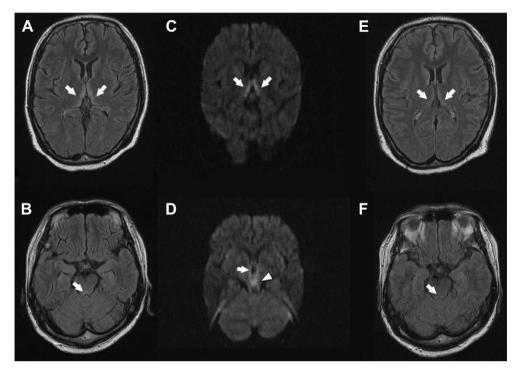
(A, B) Axial fluid-attenuated inversion recovery (FLAIR) images show abnormal hyperintensity within the medial thalami area surrounding the third ventricle (arrows in A) and pontine tegmentum (arrow in B). (C, D) Diffusion-weighted images (DWIs) show highly hyperintense areas within the bilateral thalami (arrows in C), periaqueductal area (arrow in D) and mammillary bodies (arrowhead in D) but no abnormal signal intensity in the other brain regions. These lesions on DWIs are more clearly visible than on the conventional T2-weighted image. (E, F) Post-treatment axial FLAIR images show that the area of previous abnormal hyperintense areas including bilateral medial thalami (arrows in E) and pontine tegmentum (arrow in F) decreased after 3 weeks.
